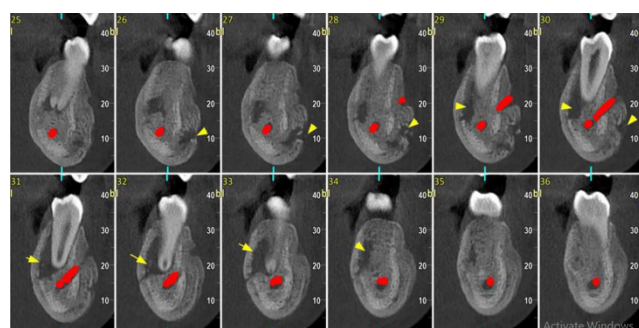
CBCT– Axial sections showing displayed tunnel like radiolucent defect on buccal cortex with onion appearance
